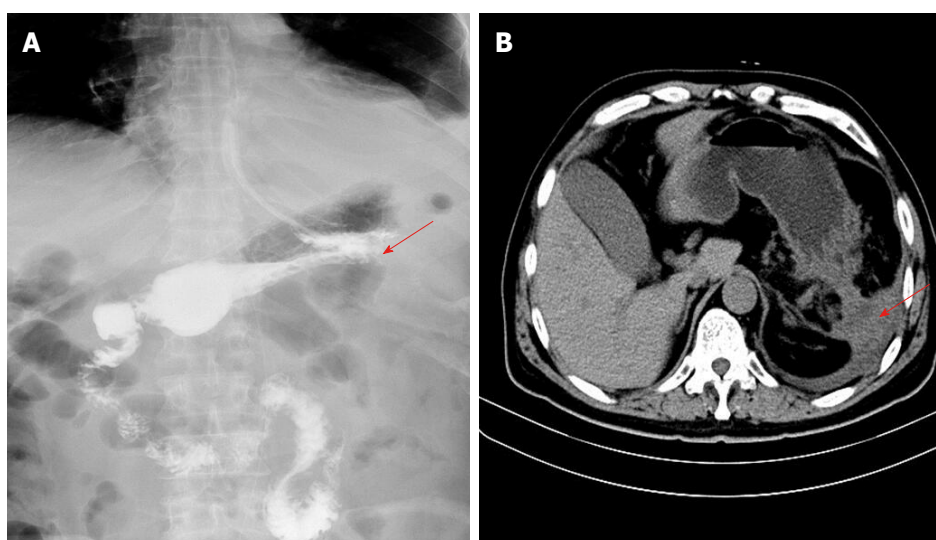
Upper digestive tract ioversol angiography findings. A: Upper digestive tract ioversol angiography showed that the gastric fistula was completely closed, and no leakage of contrast medium was observed (arrow); B: Abdominal computed tomography examination showed almost no liquid retained in the abdominal cavity, and the granulation tissue was organized (arrow).
